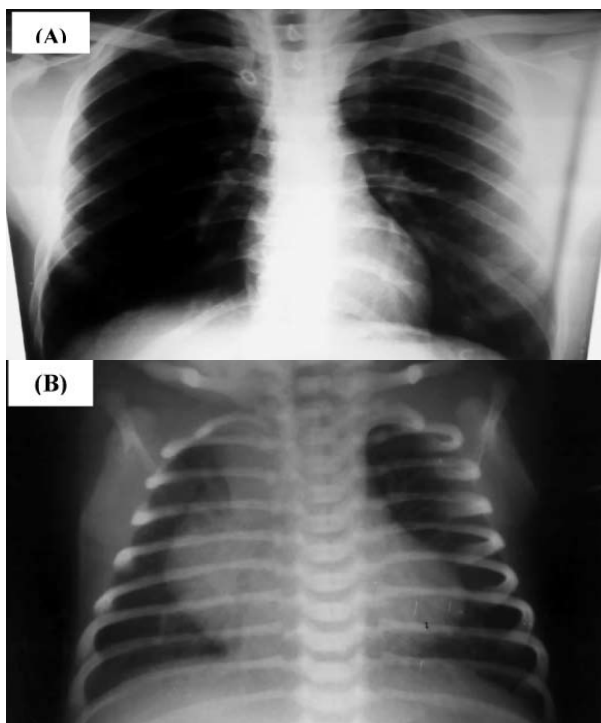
chest x-ray of aortic coarctation with (A) Rib notching. (B) Biventricular enlargement.
